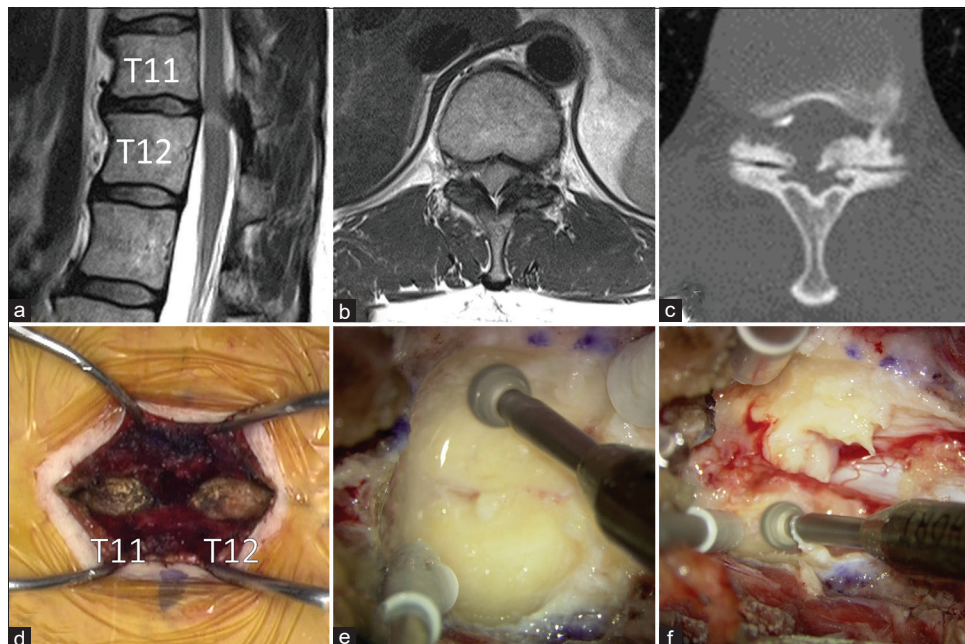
Pre- and intraoperative findings of T11/T12 ossification of the yellow ligament (OYL). (a-c) The lesion was hypointense on T2-weighted images (a and b) while the CT showed it was ossified (c). (d) The vertebral arches of T11/T12 were exposed. (e) Bilateral laminectomy of T11/T12 was performed, and a thick OYL was found. (f) The OYL was drilled thin and resected piece by piece, and the dura mater was confirmed.
